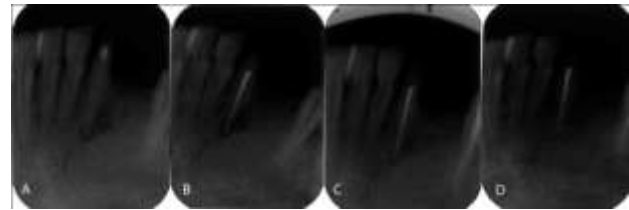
(A) Initial radiograph revealed large periapical lesion, (B) Radiograph of the root canal obturation, (C) Radiograph at one year, revealing complete repair.
